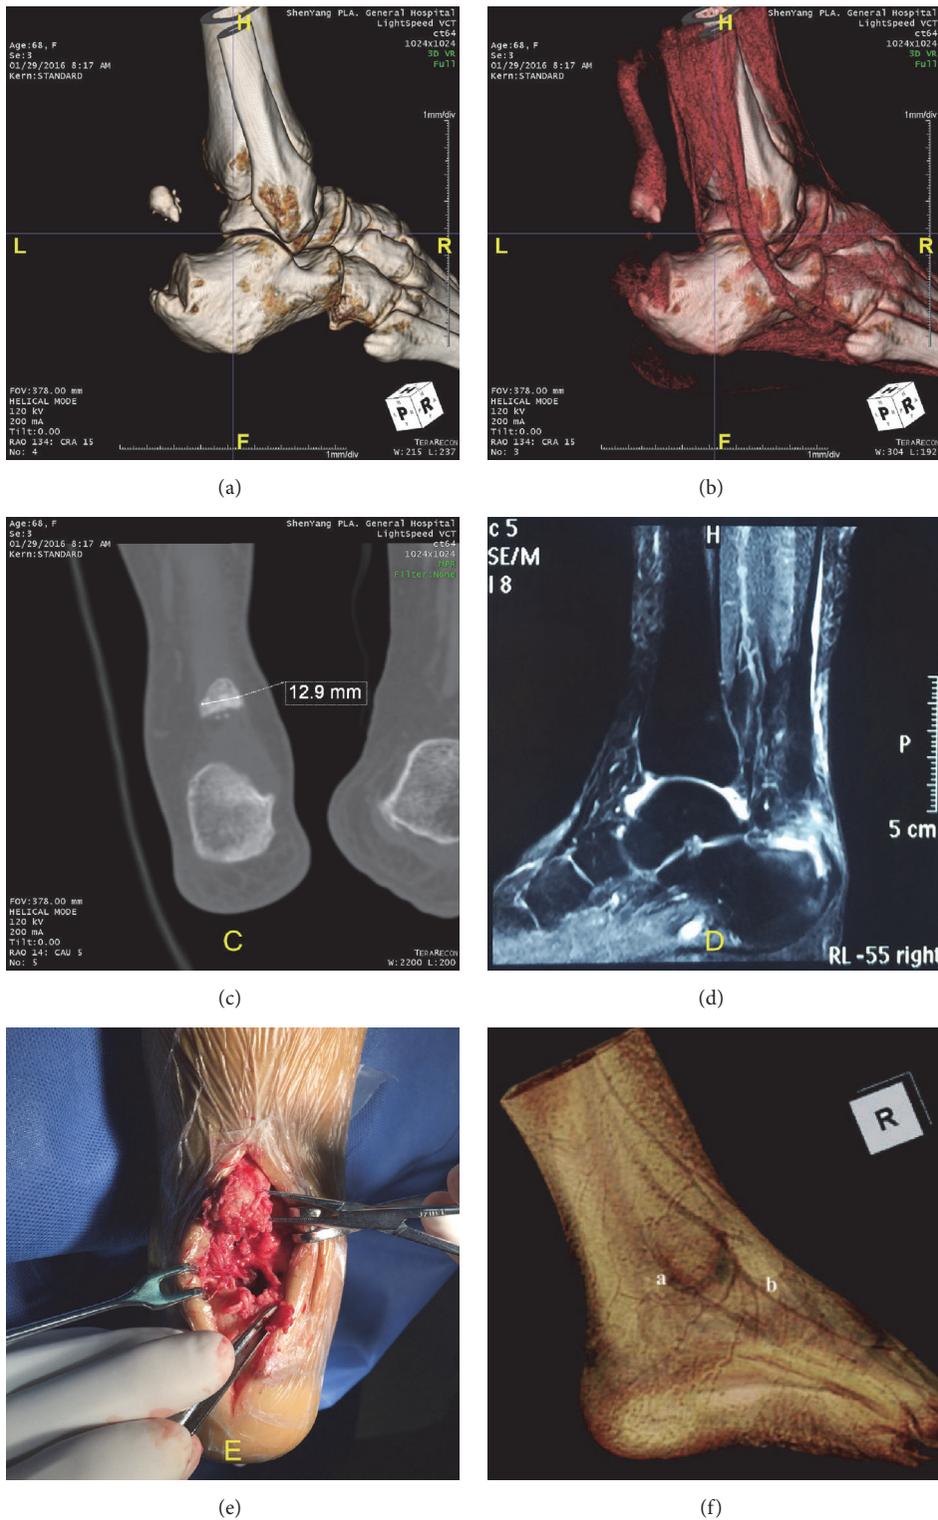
Female patient, 68 years old, hurt in the shower. (a) 3DVR image displays free bone at the back of calcaneus. (b) Widened tendon tissue image, visible Achilles tendon insertion avulsion fragment, Achilles tendon tension disappearing, and visible small tear of the Achilles tendon stump. (c) Design procedures based on bone size through PACS System. (d) The avulsion fragment cannot be seen in MRI images. (e) Achilles tendon avulsion of bone and torn tendon of distal stump observed in the surgery. (f) MRI 3DVR processed image, hard to get 3D image of Achilles tendon due to similar water content in Achilles tendon and the surrounding tissue (image from [32]).
